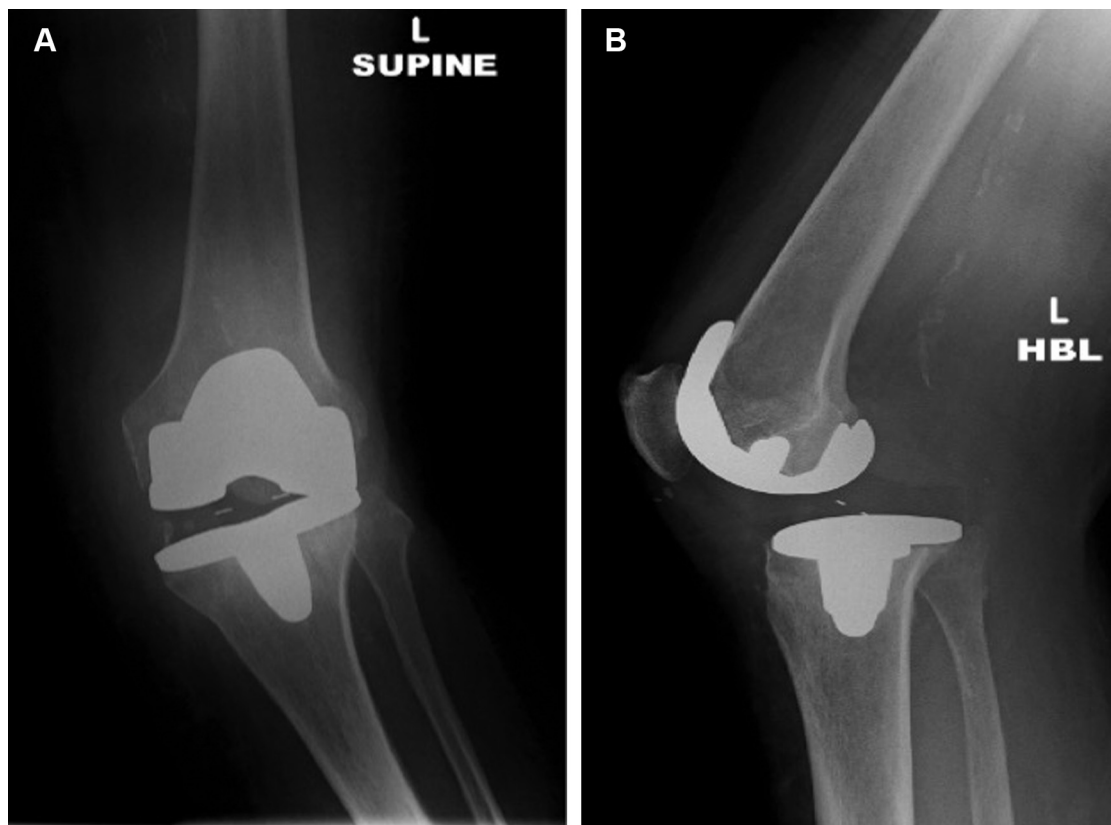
(A) AP X-ray of a spinout. (B) Lateral X-ray of a spinout.
